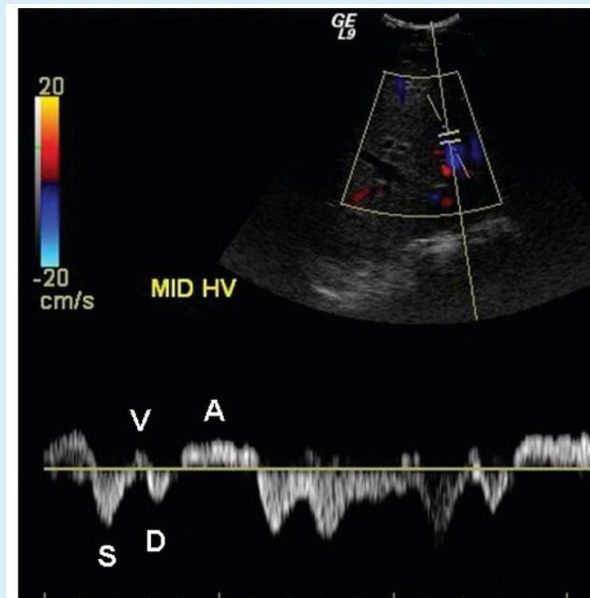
Normal spectral Doppler waveform of the middle hepatic vein.
